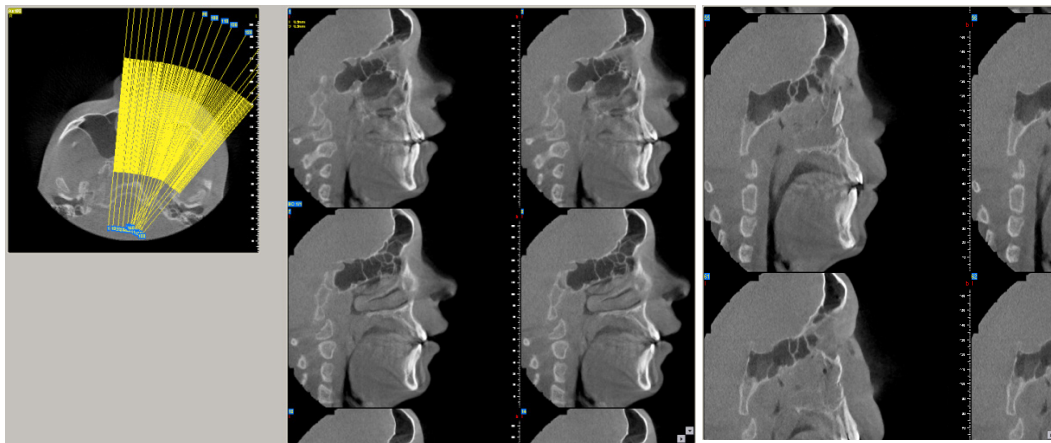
CBCT. Additional inclination of the designed curve for sagittal sections.
